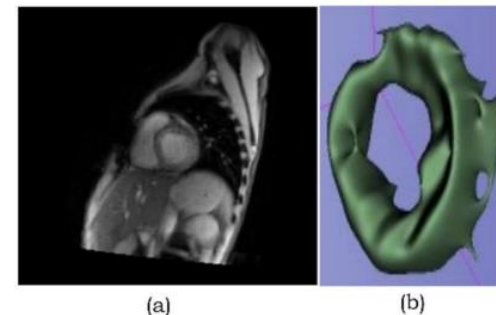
(a) cardiac MRI image from the database, (b) segmented myocardium
